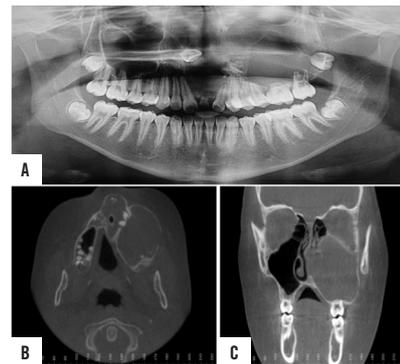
A) panoramic radiograph showing an extensive radiolucency extending from the upper right central incisor to the upper left third molar. Note the presence of radiopaque foci and root resorption of the teeth closely associated with the lesion; B) axial and C) CBCT images showing the large dimensions of the lesion
